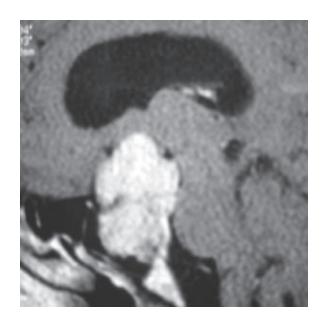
MRI of the brain sagittal view shows vertical extension of giant macroadenoma compressing the hypothalamus and third venticle
